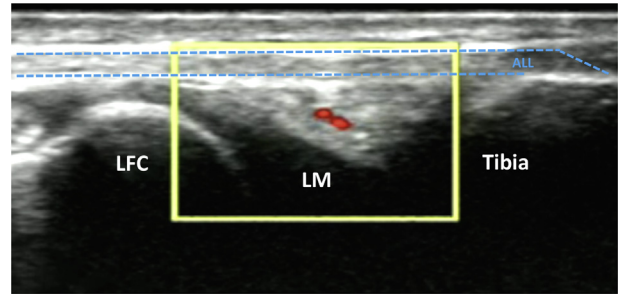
Doppler ultrasonography is used to view the blood flow in the lateral inferior genicular artery, which is in red here. This structure is located between the anterolateral ligament and the lateral meniscus (LM). For this right knee, distal is to the right and proximal is to the left. (LFC, lateral femoral condyle.)
